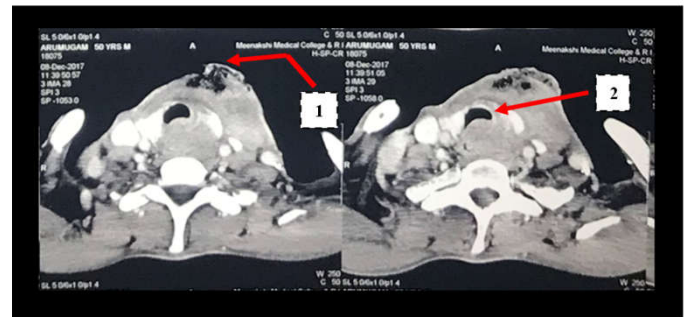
Computed Tomography showing air pockets in subcutaneous plane (labelled as 1) and anterior displacement of trachea (labelled as 2).
